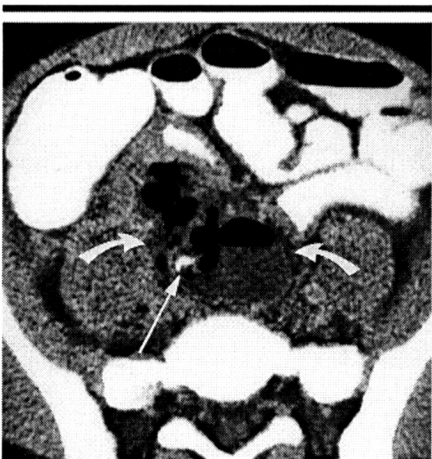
Perforated appendicitis. Transverse CT scan through the upper part of the pelvis after the administration of intravenous and oral contrast material in an 8-year-old girl with acute right-lower-quadrant pain demonstrates a complex collection (curved arrows) of low-attenuating fluid and air. Note the punctate area of high attenuation (straight arrow) within the collection, which represents an appendicolith. At surgery, a perforated appendix and a periappendiceal abscess were noted.
